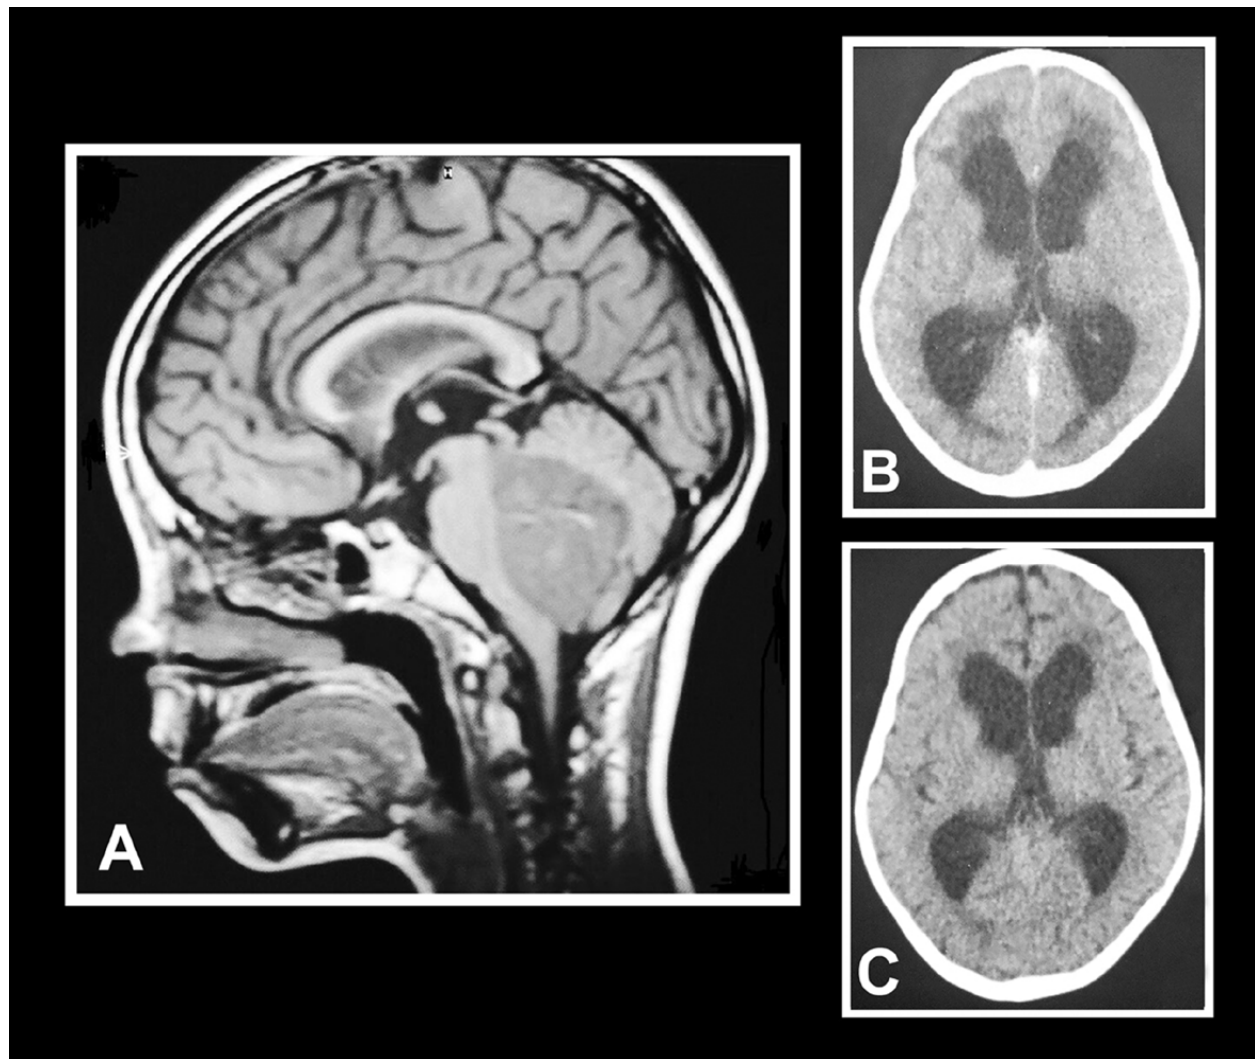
A: Magnetic resonance imaging T1 weighted sagittal view of a case of posterior fossa tumor (medulloblastoma), demonstrating communication between third ventricle and prepontine cistern after endoscopic third ventriculostomy . B: Preoperative axial CT scan image showing severe obstructive hydrocephalus due to posterior fossa tumor. The presence of massive periventricular edema signifies acutely occurring hydrocephalus. C: Postoperative axial CT scan image obtained 3 days after endoscopic third ventriculostomy showing mild reduction in ventricular size, resolution of periventricular edema, and opening of subarachnoid space. [Reprinted with permission from El-Ghandour NM (2011). Endoscopic third ventriculostomy versus ventriculoperitoneal shunt in the treatment of obstructive hydrocephalus due to posterior fossa tumors in children. *Childs Nerv Syst*, Vol. 27, No. 1, (January 2011), pp. 117-126, ISSN 0256-7040].
